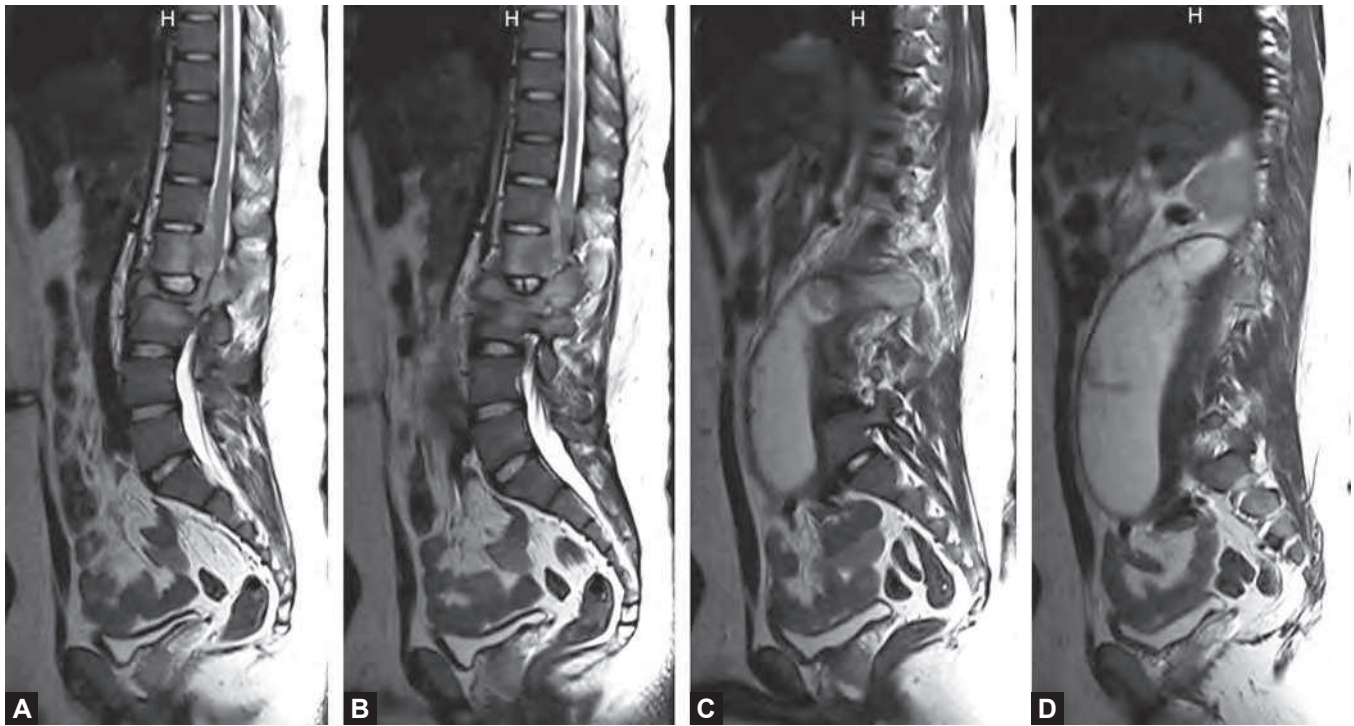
The extent of abscess formation in tuberculosis does not match the severity of vertebral damage. The lumbosacral radiographs of this patient do not show any vertebral damage. But the patient has extensive abscesses collected in the paravertebral, pelvic, and iliac regions. Except for back pain, he was asymptomatic.
